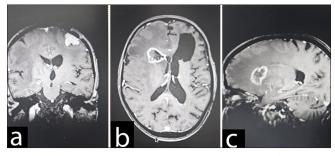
MRI Brain revealing (a) partially excised left posterior frontal meningioma and (b,c) right frontal glioma.
